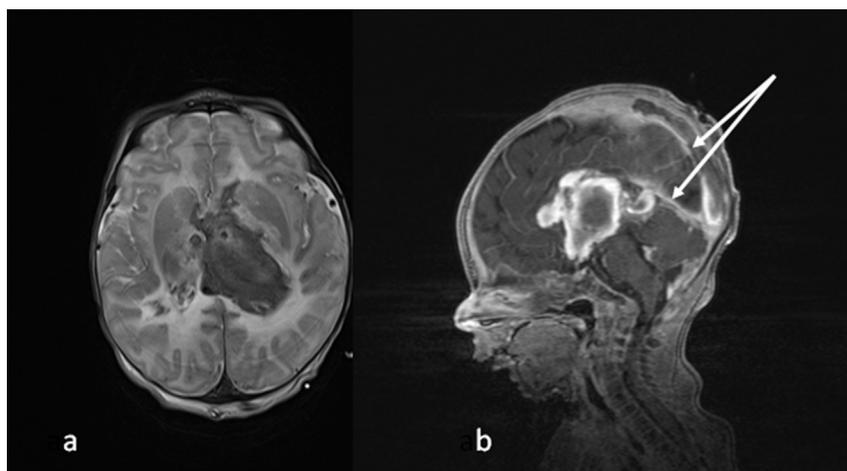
Five-day-old term neonate who presented abruptly with lethargy and opisthotonus. A large thalamic haemorrhagic stroke is seen on this axial T2-weighted image with contiguous intraventricular haemorrhage. On contrast-enhanced MR venography, large filling defects corresponding to extended thrombi are seen (double-arrow) along the superior sagittal sinus and the straight sinus.
